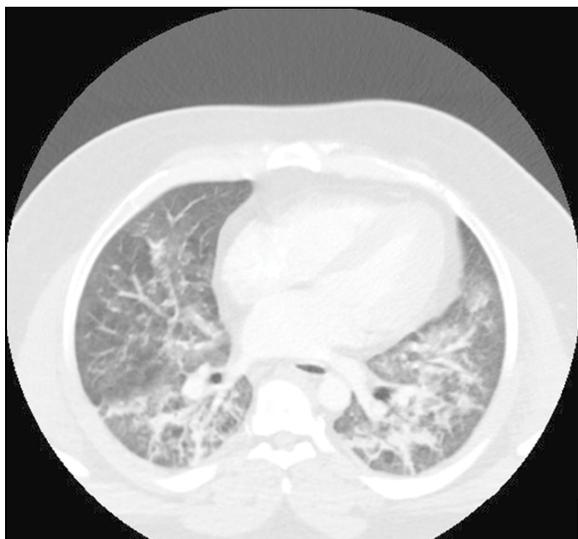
CT chest image highlighting diffuse interstitial infiltration also consistent with ARDS
